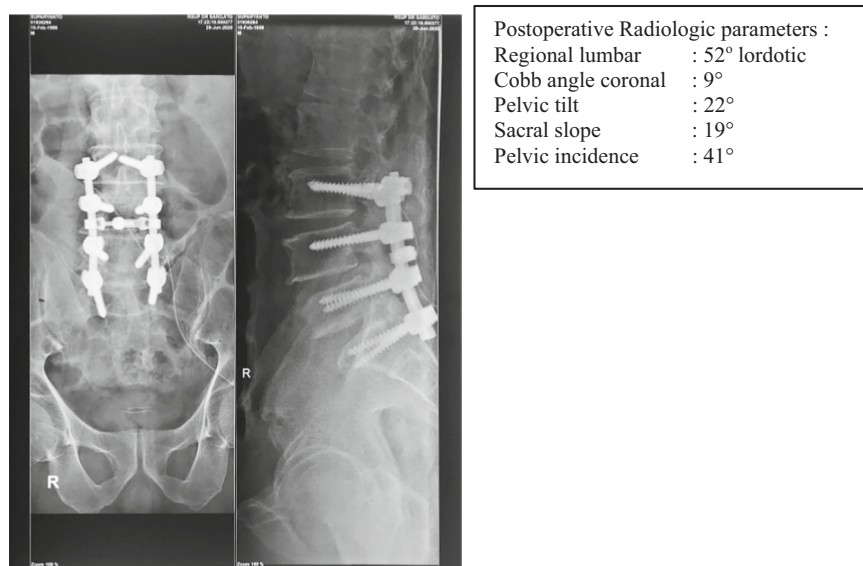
Case 6 Postoperative radiograph.
